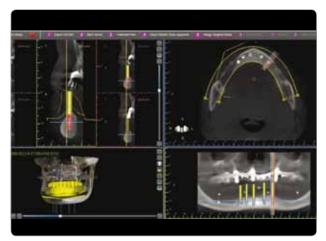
CBCT of the patient with the scan appliance
